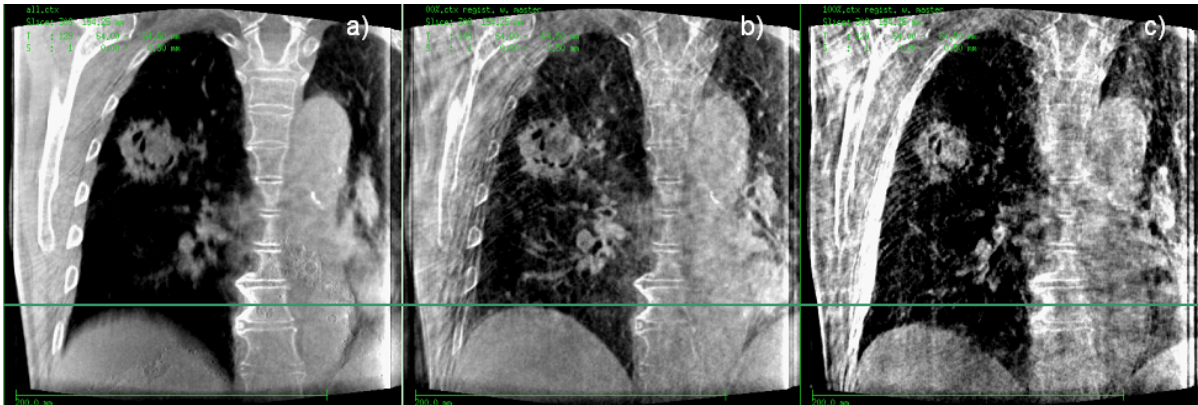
CBCT reconstructions of a 4D-CBCT data-set
